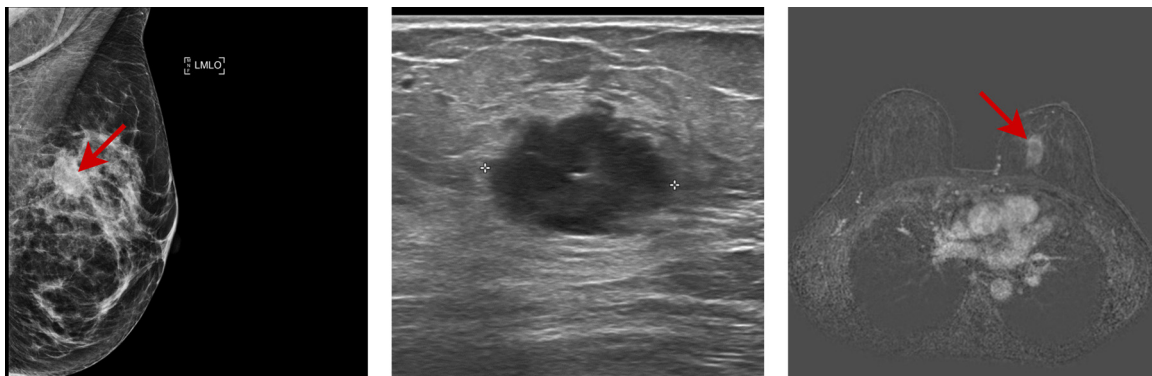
Digital mammography, ultrasound and magnetic resonance scans of a 45 y old woman with an infiltrating ductal carcinoma in the left breast, indicated with the red arrows. Left: digital mammography, middle: ultrasound, right: magnetic resonance.
